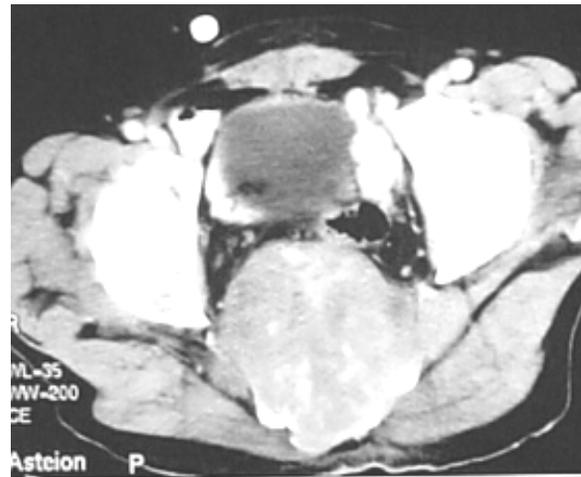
CT scan of the pelvis showing trivial enlargement of prostate and chordoma.
